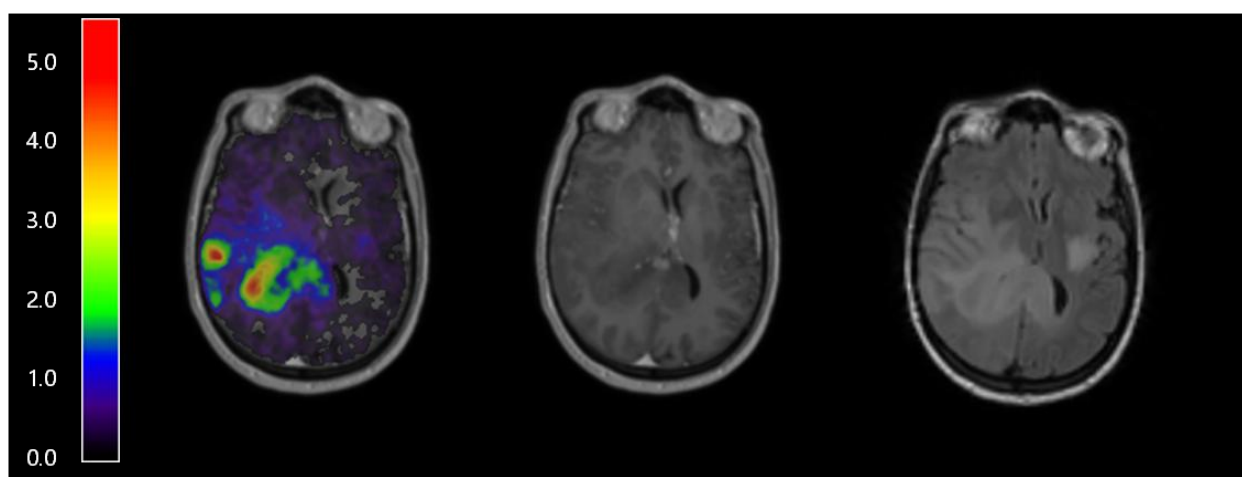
(a,b,e,f) Coregistered axial T1 post-contrast and axial T2 FLAIR MR scan images showing non enhancing lesions delineated according to the FLAIR hyper-intense signal change. (a,b) Anaplastic Oligodendroglioma WHO III. (e,f) Oligodendroglioma WHO II (c,g) Corresponding 11C-PK11195 binding potential parametric maps overlaying coregistered post-contrast T1 axial images. (d,h) Coregistered rCBV maps derived from T2\*.
